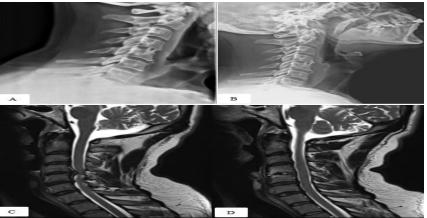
ACDF with PEEK cage at C4-5 A, B) sagittal cervical radiographic; A: (postoperative 1st month) showing anterior displacement of the PEEK cage and B: (postoperative 3rd month) showing no cage distraction despite the neck exercises. C, D)
